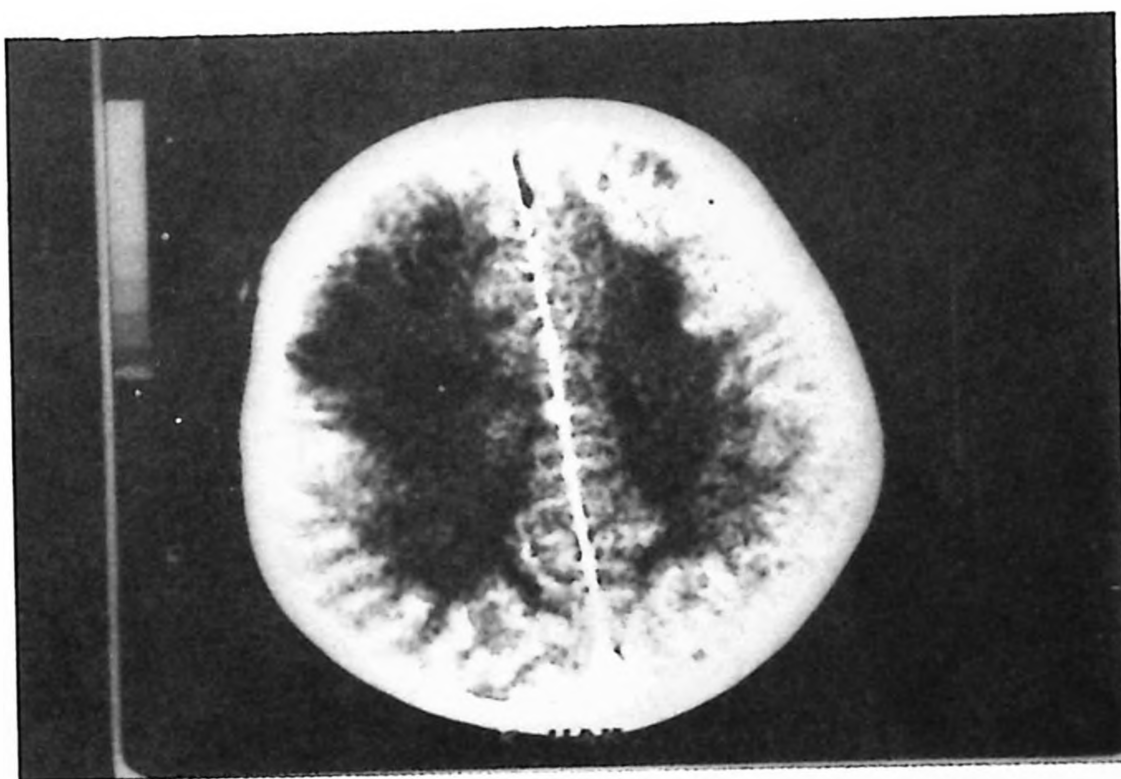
a: CT of Case 1: Multiple low-density areas in the right temporal-parietal and left parietal regions.
